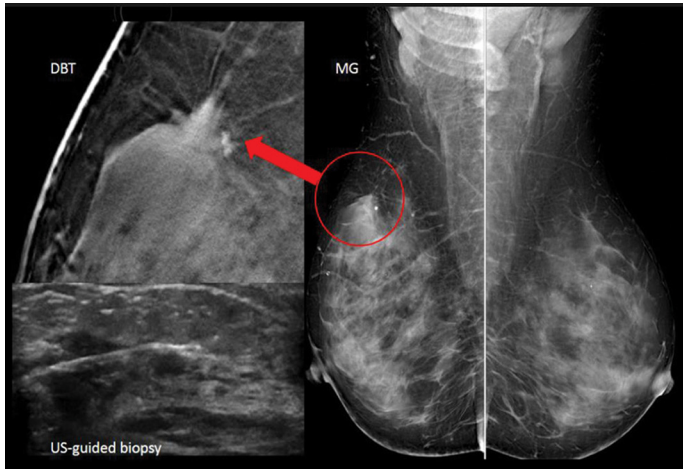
Digital breast tomosynthesis for breast carcinoma. A 42-year-old female patient with breast carcinoma. A dense breast pattern is seen. Digital breast tomosynthesis (DBT) shows the mass and its spiculated margins more prominently than digital mammography (MG). On MG, it is not easy to see the carcinoma. Ultrasonography-guided biopsy confirmed the diagnosis of carcinoma
